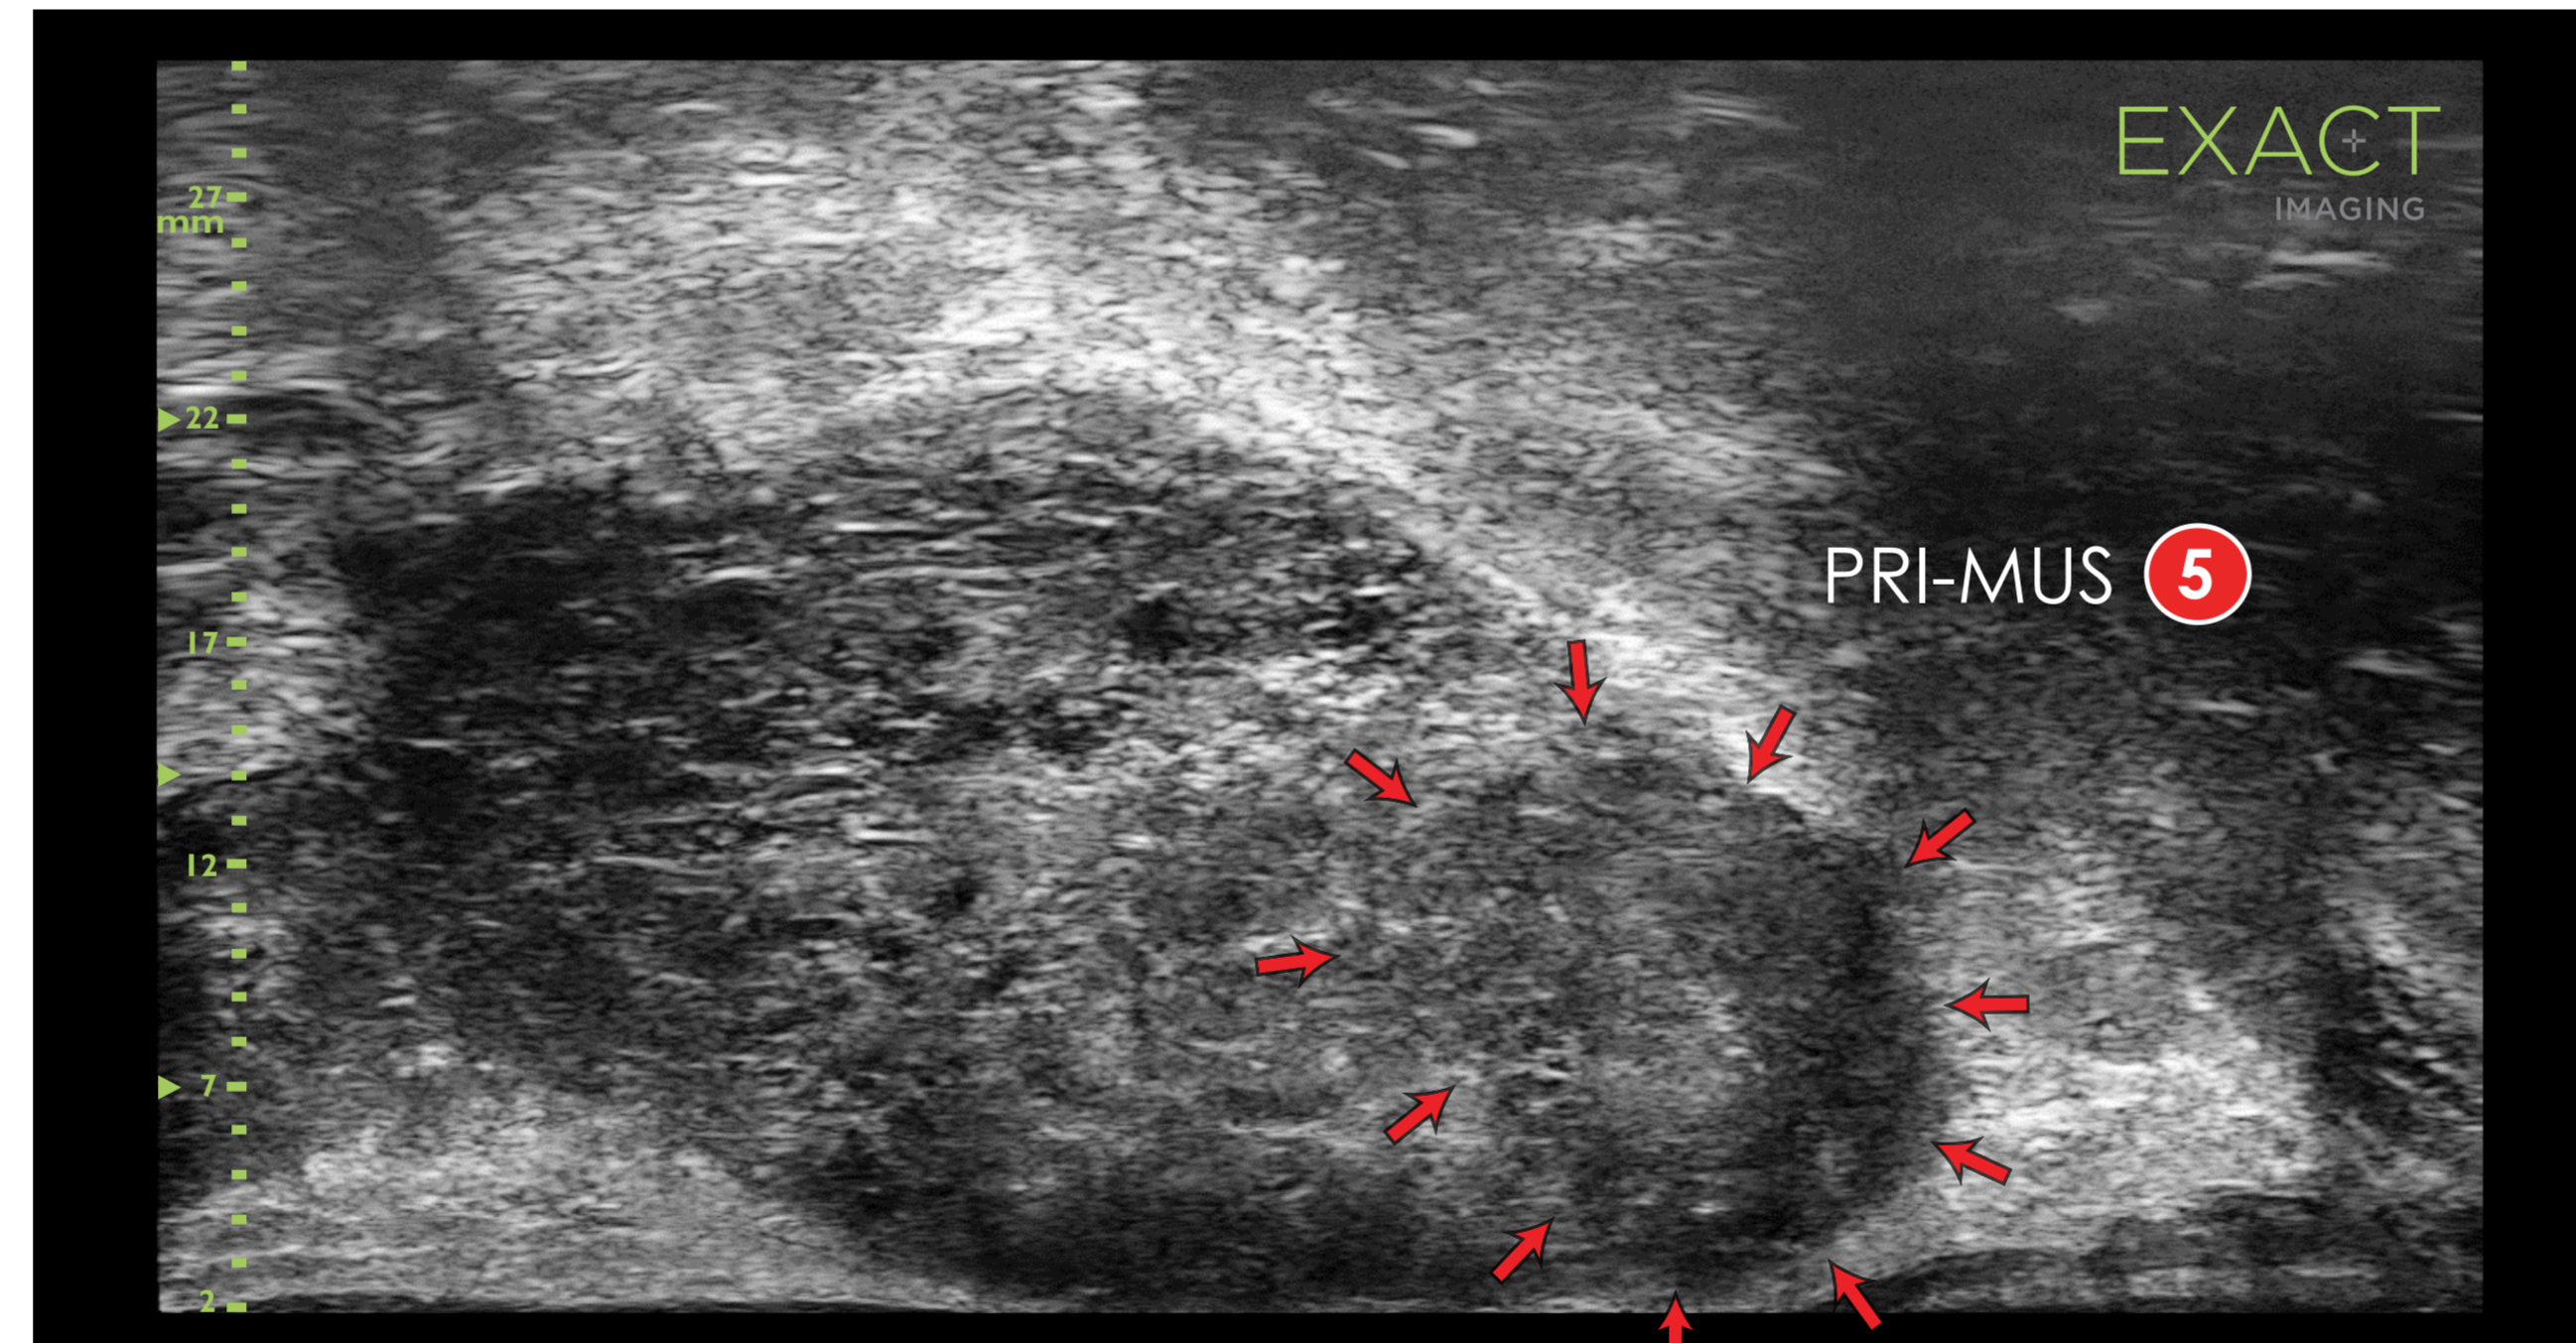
Apex lateral PRI-MUS 5 mixed-echo lesion. Biopsy of this area confirmed Gleason 7 cancer with 80% core length. Micro-ultrasound scale is in mm.
